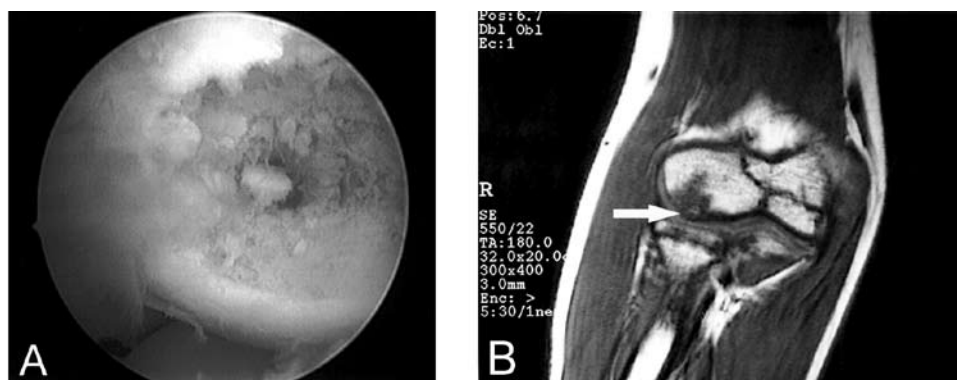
Osteochondritis dissecans of the humeral capitellum in a young water polo player. (A) Arthroscopic view of the lesion situated on the posterolateral aspect of the humeral capitellum; (B) magnetic resonance imaging of the same patient (white arrow indicates the lesion).
